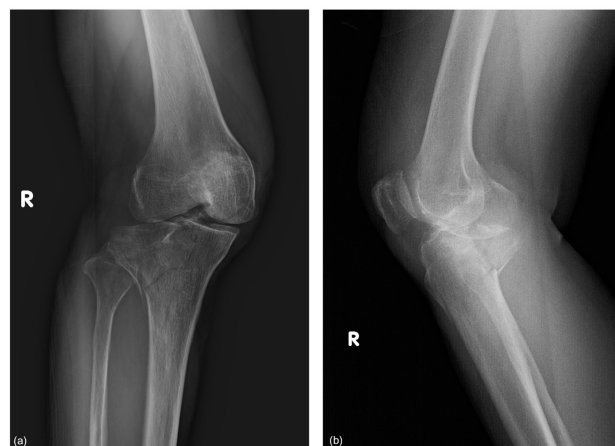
Pre-operative radiographs of the right knee.
